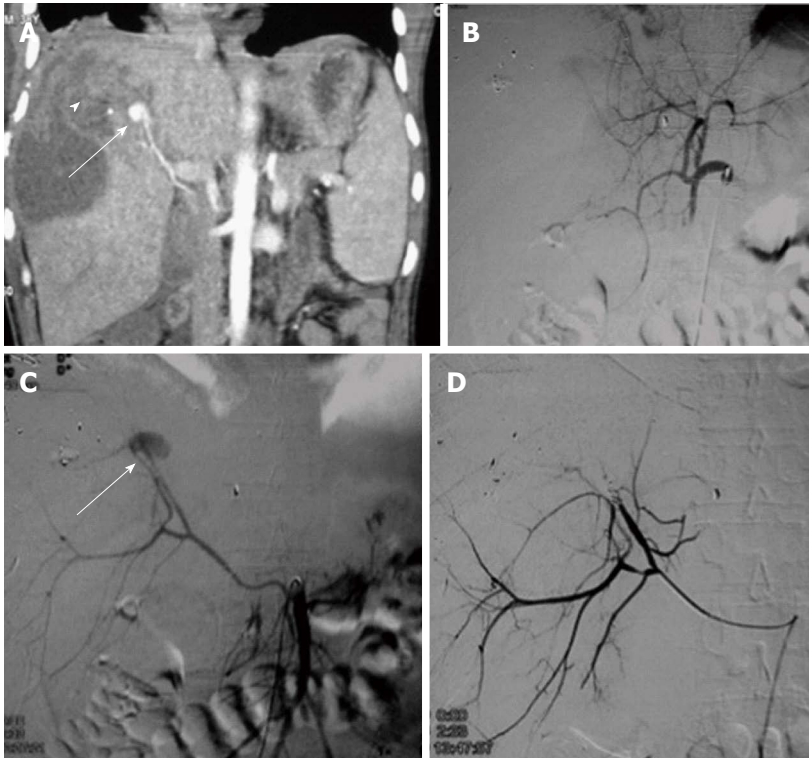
Gun shot injury with hepatic artery pseudoaneurysm. A 38-year male with gunshot injury presented after a week with falling hematocrit. A: CECT showed a contrast filled outpouching in segment VIII of liver paralleling the attenuation of adjacent hepatic artery branch s/o PsA (arrow) with adjacent subcapsular hematoma (arrowhead) subsequently DSA was done; B: Initial hepatic angiogram showed opacification of only branches of left lobe of liver, no opacification of right hepatic artery -s/o variant anatomy; C: SMA angiogram showed replaced right hepatic artery with PsA arising from the terminal end of anterior division (arrow). Due to smaller caliber and spasm, neck of the PsA could not be negotiated, hence, proximal embolization with microcoils was performed; D: Post embolization angiogram showed faint opacification of branches of anterior division of RHA along with exclusion of PsA. CECT: Contrast enhanced computed tomography; RHA: Right hepatic artery; PsA: Pseudoaneurysm; SMA: Superior mesentery artery; DSA: Digital subtraction angiography.
